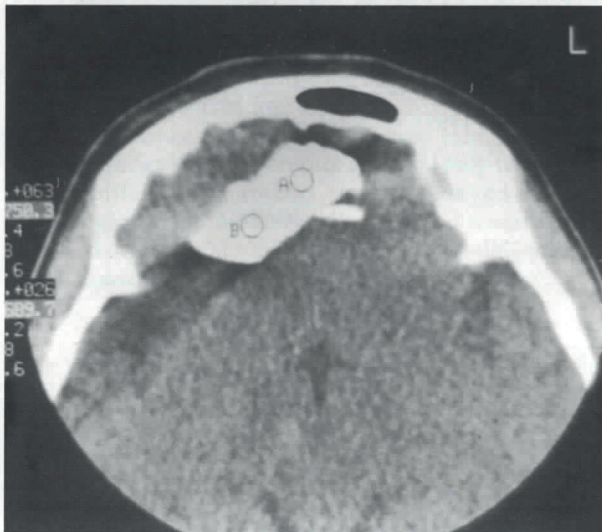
CT demonstrating intracerebral hyperdense foreign body and bone fragments.
